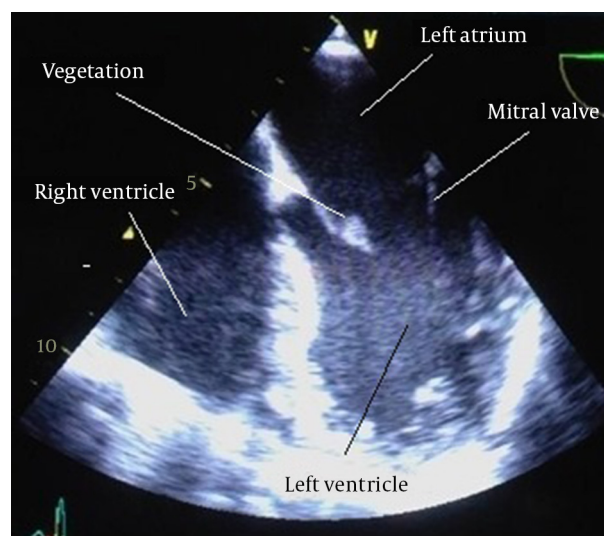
Four-Chamber Transesophageal Echocardiography, Showing Vegetations
